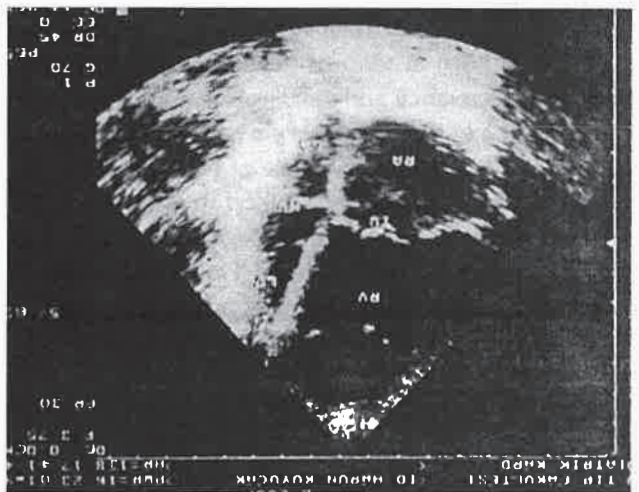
Apical four-chamber two-dimensional echocardiogram from patient shows markedly dilated right heart chambers with a shift of the interventricular septum toward the left
